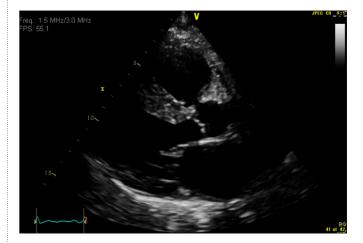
Echocardiogram showing antero-septal hypertrophy.
